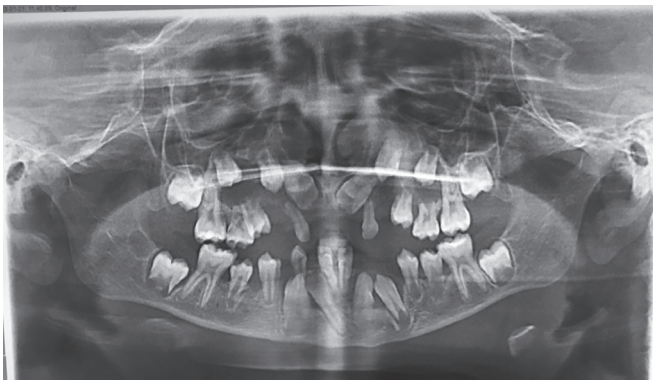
Postoperative orthopantomogram, 3 months
